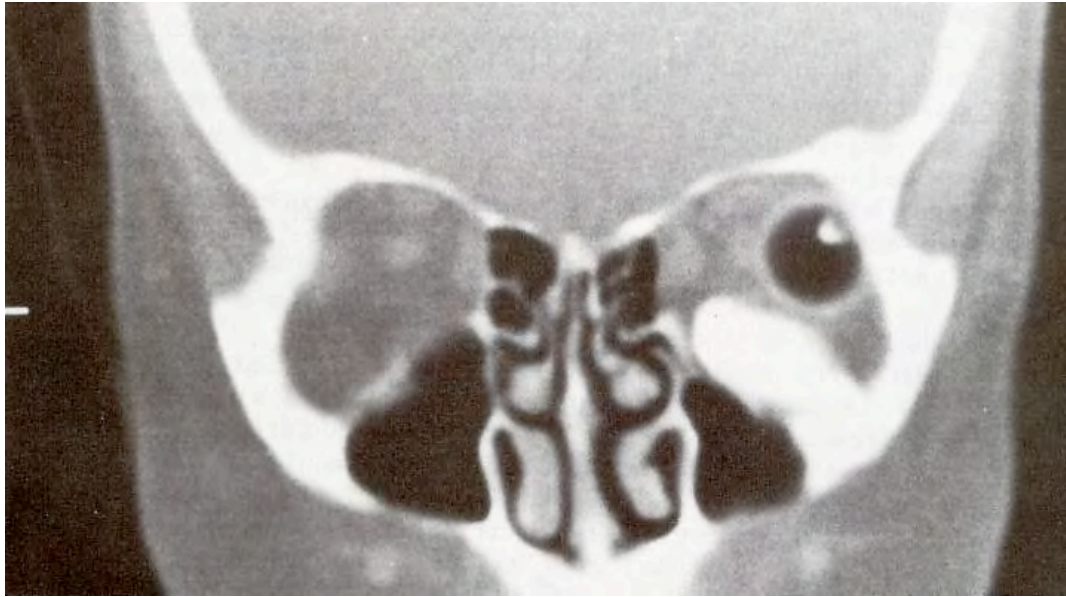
An HAPEX™ implant in the orbital floor of a patient who has lost an eye. The HAPEX™ implant is shown on the right of the image with the same radiographic density as the bone to which it is bonded while the spherical black object is a glass ball implanted in an earlier attempt to increase the volume of material in the orbital socket (from Downes *et al.*, 1991)
